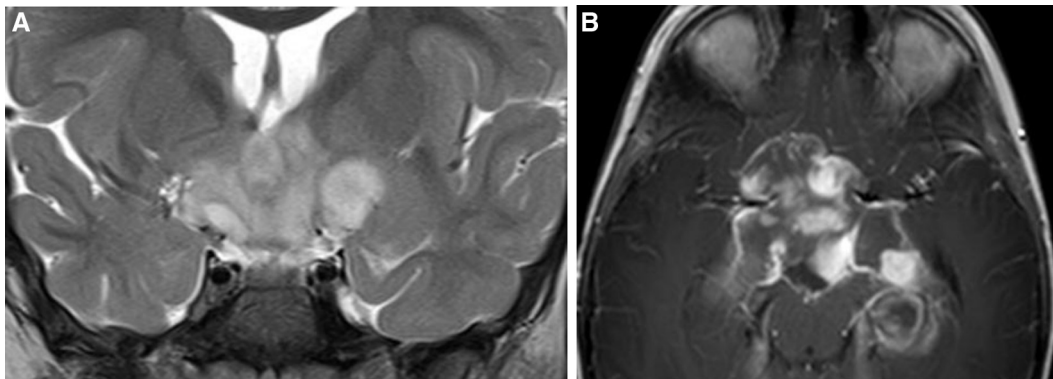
Optic pathway glioma: a 3-year-old boy with an infiltrative supratentorial mass lesion. (A) Coronal T2-weighted imaging showing bright signal and (B) axial postcontrast image showing heterogeneous and rim enhancement (panel B obtained 2 years after panel A). The lesion arises from the optic chiasma and extends into the surrounding structures including bilateral basal ganglia, bilateral mesial temporal lobes, and bilateral basal frontal lobes.
